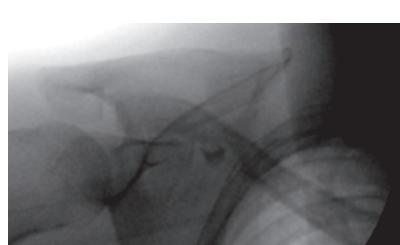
X-ray demonstration of Caudad tilting of C-arm.
